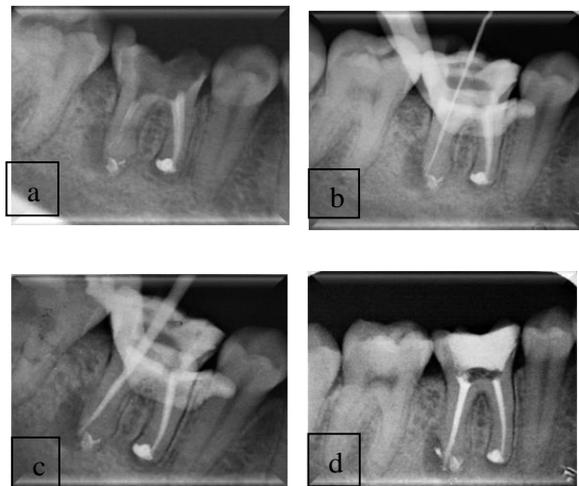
Periapical radiograph of tooth 46 (a) Radiographic view after removing Guttapercha, (b) Radiographic view working length, (c) Try in gutta percha, (d) After obturation
